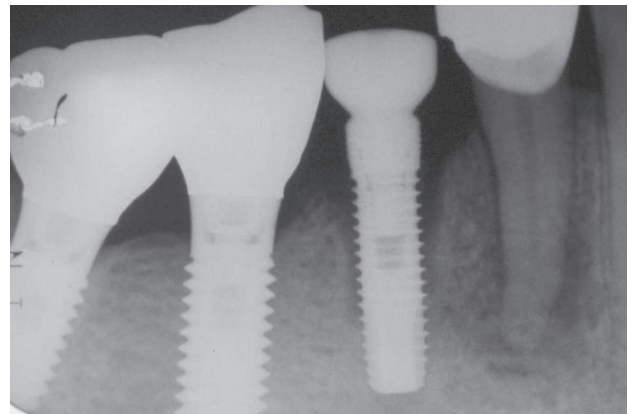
Radiograph demonstrating a defect area involving six macro threads around the implant and radiolucency at the apex of the first premolar.
